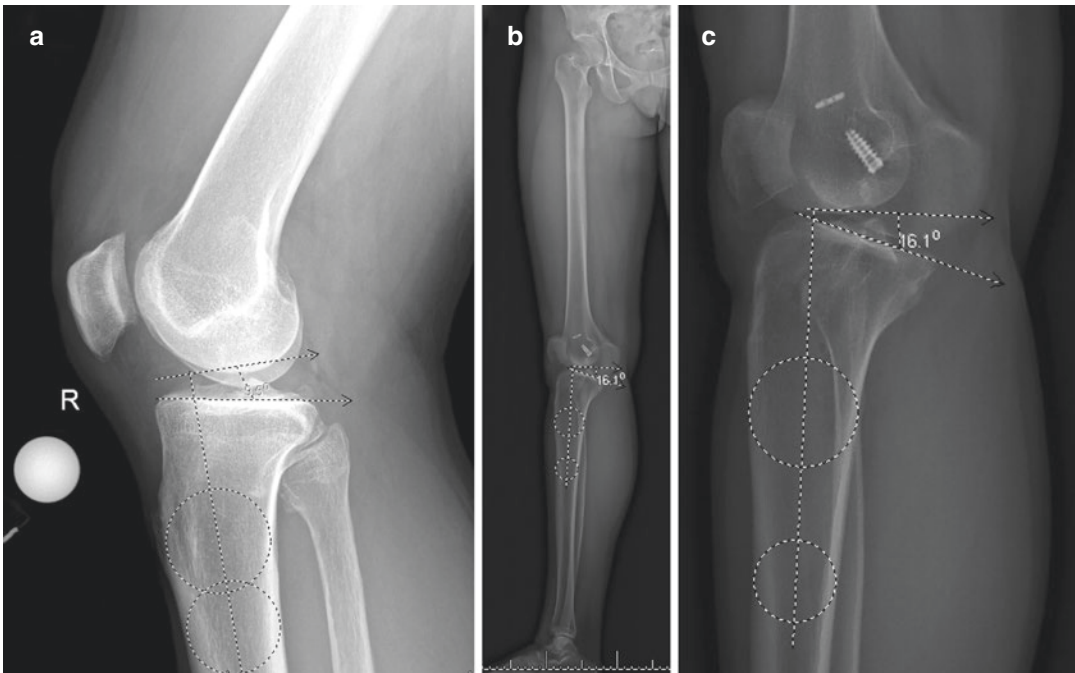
Measurement of posterior tibial slope. A lateral radiograph (a) is shown with a measurement of the posterior tibial slope. Briefly, to identify the longitudinal axis of the tibia, a line is drawn connecting the center of the tibia at 2 points about 5 cm apart and with the distal point as distal in the tibia as possible. A second line is drawn connecting the anterior and posterior most points on the tibial plateau. The angle between a line perpendicular to the longitudinal axis of the tibia and the line tangential to
